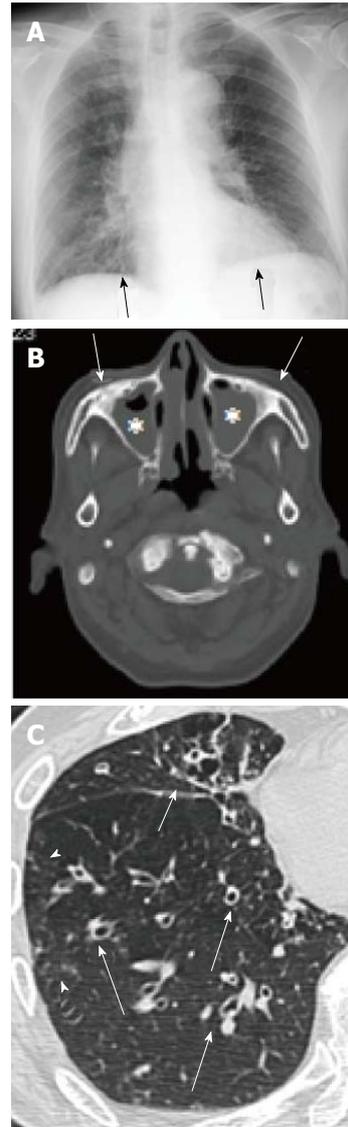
Sinobronchial syndrome in a man in his 70s. A: Chest radiograph shows bilateral reticulonodular opacities in both lower lung fields (arrows); B: computed tomography (CT) at the level of maxillary sinus demonstrates opacification of the maxillary sinuses (*) and bone sclerosis of the sinus walls (arrows), suggestive of chronic paranasal sinusitis; C: Thin-section CT reveals bronchial wall thickening with bronchiectasis (arrows) and minimal centrilobular opacities (arrow heads).
